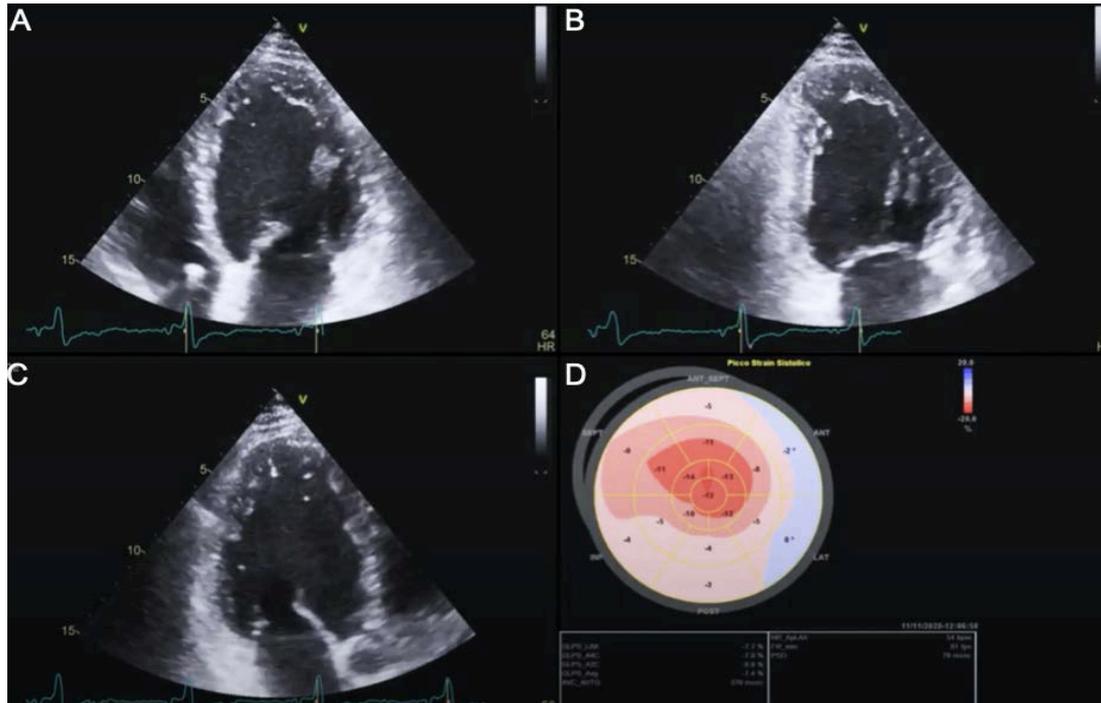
Speckle tracking echocardiography from personal archive. A-apical long-axis view 4 chambers. B-apical long-axis view 2 chambers. C-apical long-axis view 3 chambers. D-Bull's-eye plot.
